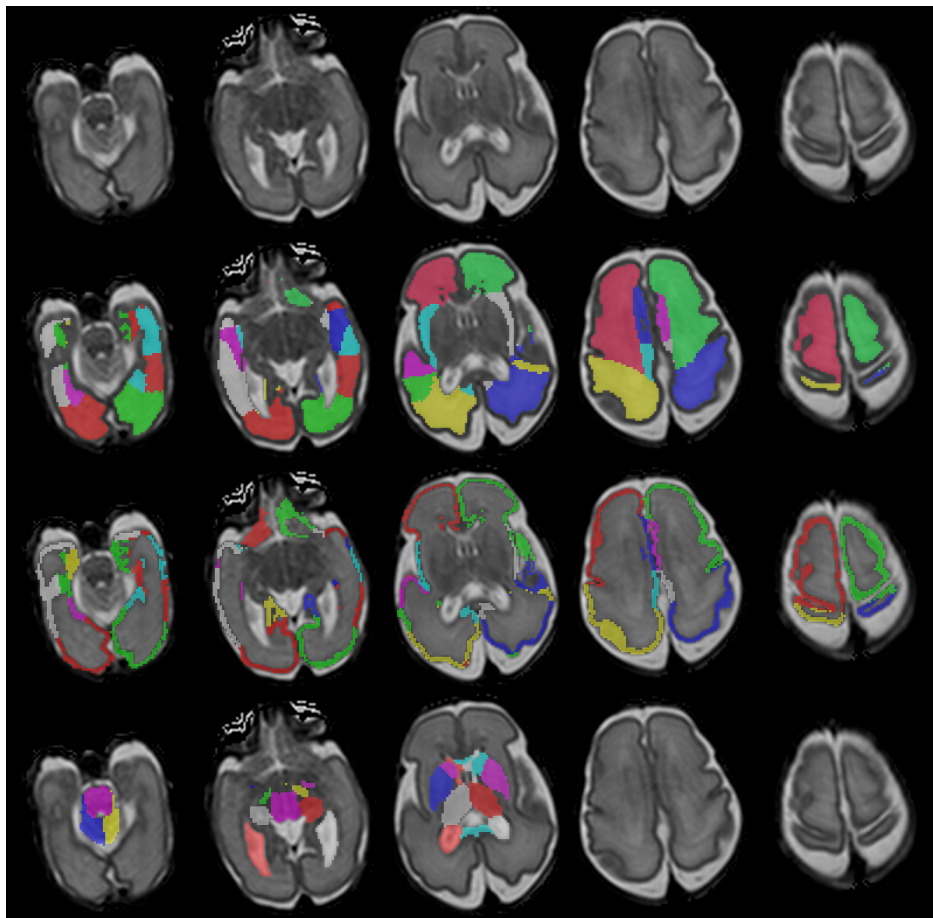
Example segmentation of a neonatal MRI acquired at 28 weeks age at scan with the 82 labels overlaid (second row: WM labels, third row: CGM labels, fourth row: subcortical GM labels and ventricles).
